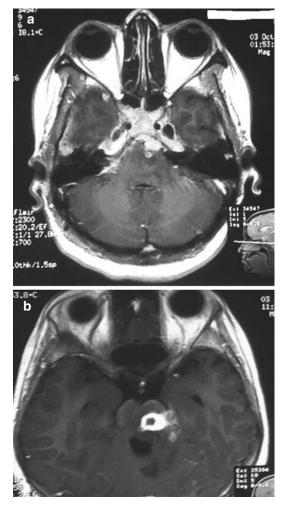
Contrast-enhanced MRI showing homogeneous and ring-enhanced tuberculomas in the brainstem (a, b) along with basal meningeal enhancement (a)
